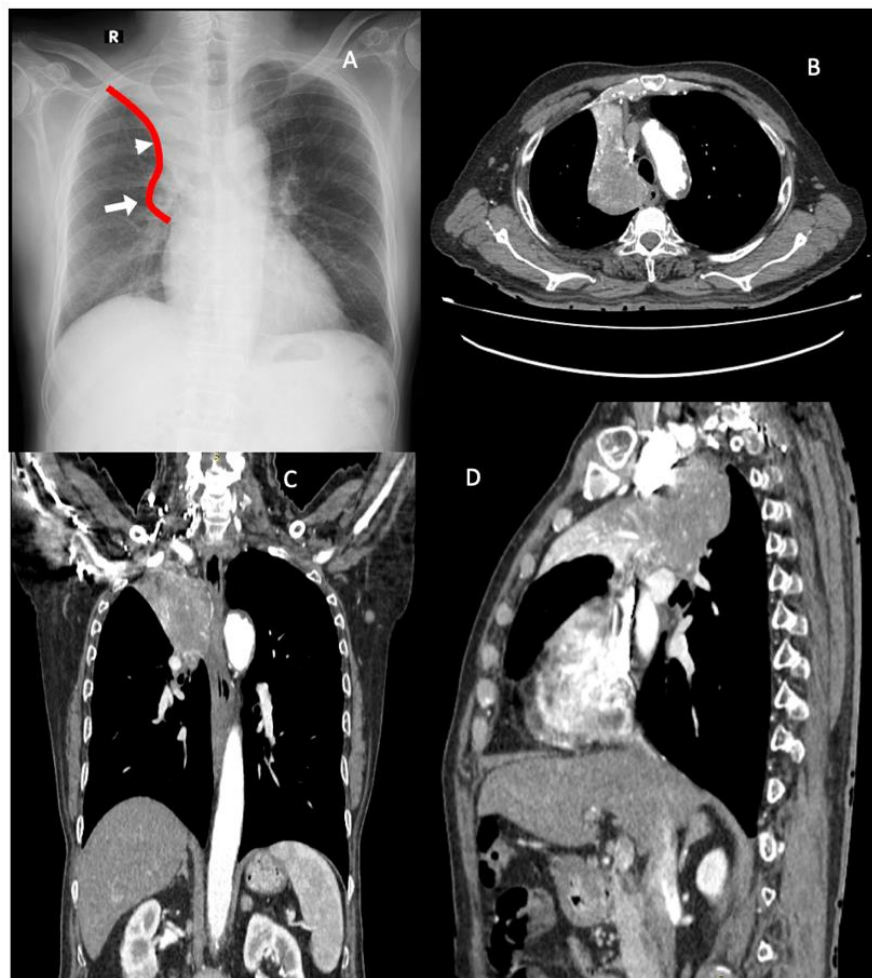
(A) Posteroanterior radiograph of the chest with golden S sign. Convexity (arrow) from the mass and concavity (arrowhead) of the minor fissure (B) Axial (C) Coronal (D) Sagittal views of contrast-enhanced CT showing Right upper lobe lung carcinoma with adjacent tissue infiltration and nodal and left adrenal metastases
